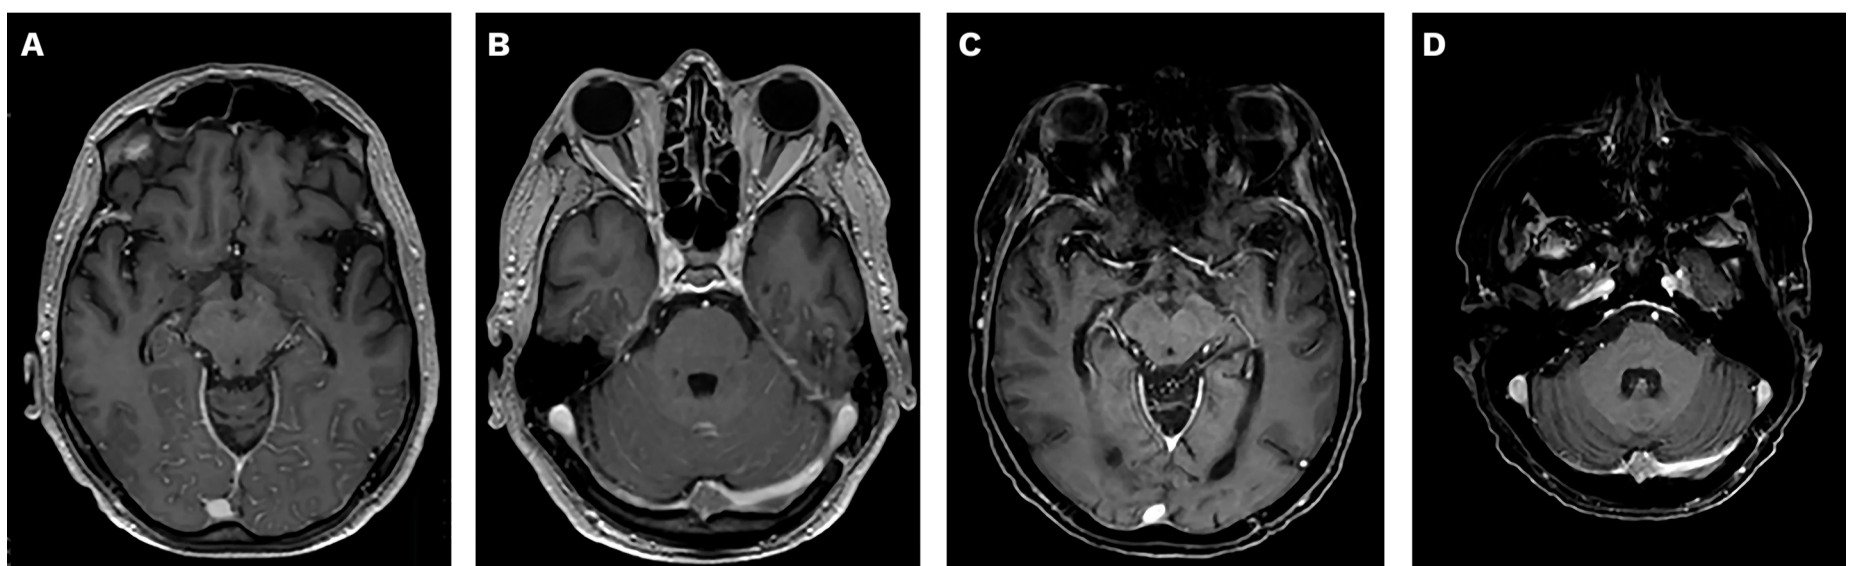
Brain T1 magnetic resonance imaging with gadolinium. (A and B) Axial T1 magnetic resonance imaging (MRI) with gadolinium day 41, leptomeningeal enhancement in the cerebellar and occipital cerebrospinal fluid. (C and D) Axial MRI T1 with gadolinium day 81, leptomeningeal enhancement resolved.
